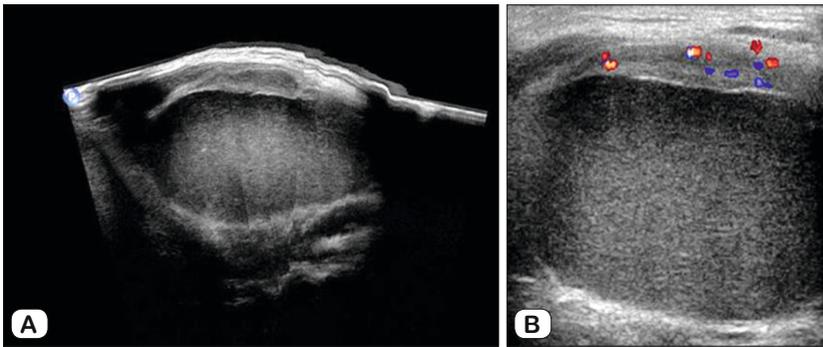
Ultrasonographic finding of a brachiogenic cyst (A), Doppler (B)
